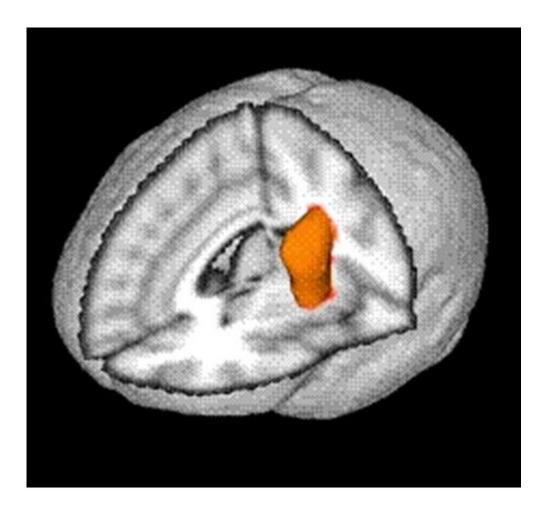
T1 weighted structural MRI: image shows stage 1 after removing the skull.
